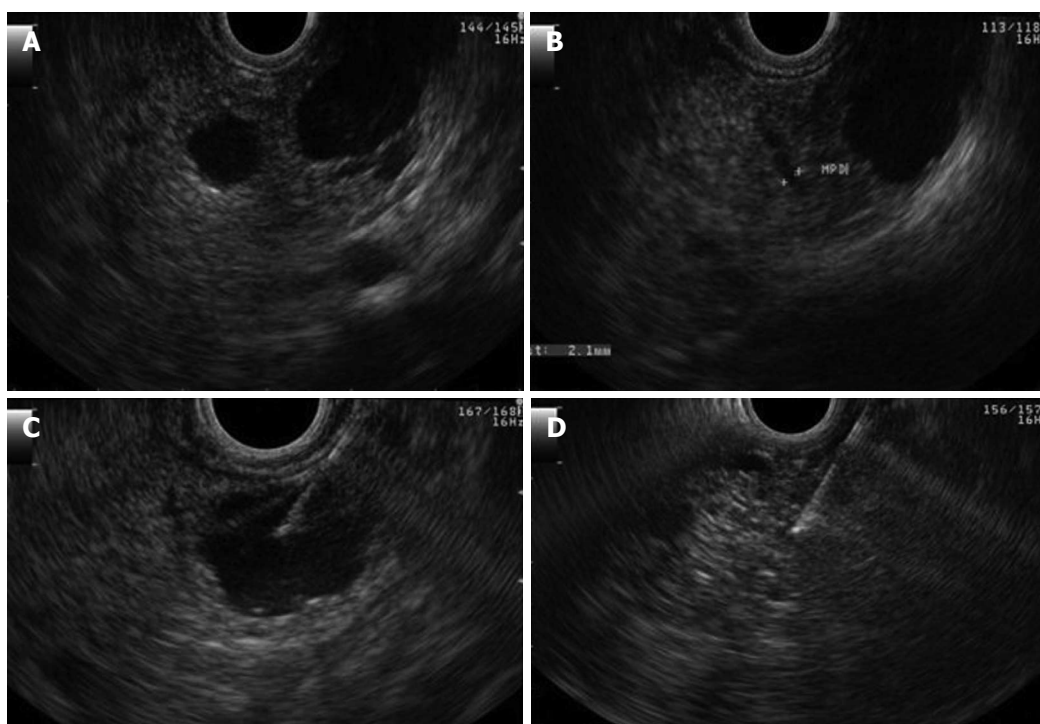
Endosonography. A, B show a large cyst of 16 mm in diameter without communication or dilatation of the pancreatic duct; C: Demonstrates aspiration of the cyst; D: Demonstrates its appearance after total aspiration.
